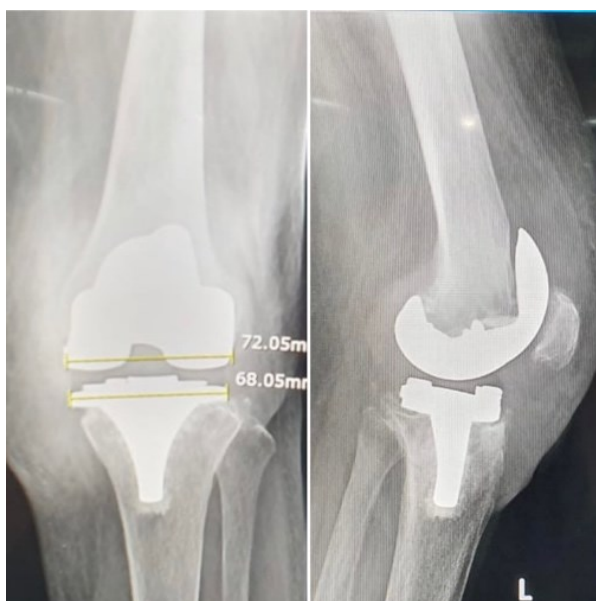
Radiograph examination of the patient showed a loosening of the medial part of the tibial base, especially along the lateral femoral condyle of knee joint.
